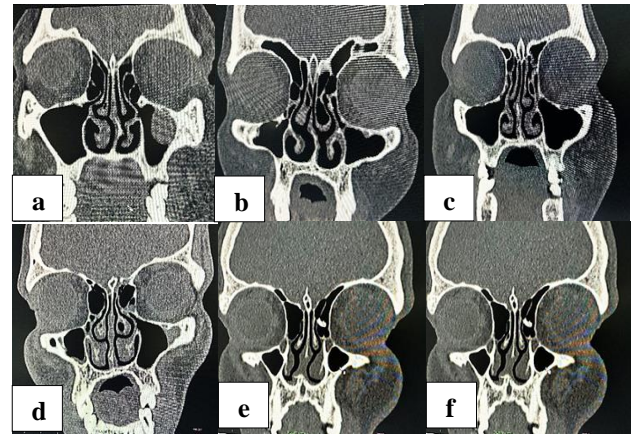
Computed tomography of paranasal sinuses depicting varying attachment of uncinale process: (a) left uncinale process attached to lamina papyrsea (LP); (b) right uncinale process attachment to agger nasi cell (ANC); (c) right uncinale attachment into lamina papyrsea and junction of middle turbinate with cribriform plate (MTCP); (d) left uncinale attachment into the junction of middle turbinate with cribriform plate (MTC); (e) left uncinale shows attachment to ethmoidal skull base (ESB); and (f) right uncinale shows attachment to middle turbinate (MT).
